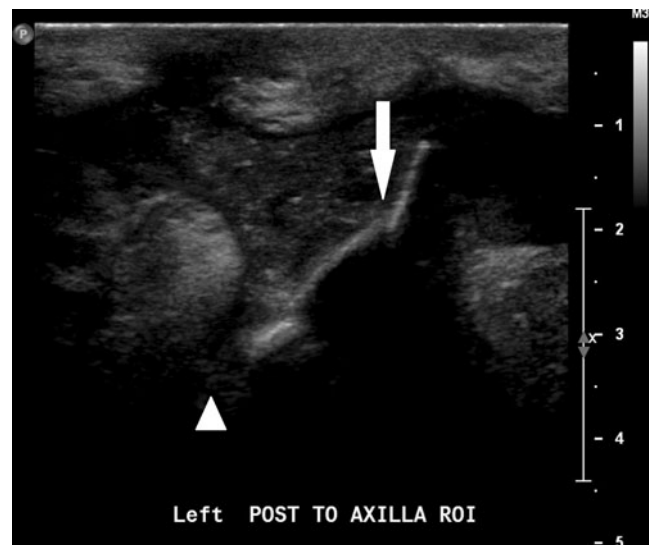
Left axillary ultrasound image showing foreign bodies within the left axillary region measuring 4.6×3.4 cm (arrow) that were 5 mm from the skin surface. There was also a smaller piece superior to the largest fragment measuring 6 mm, 4 mm from the skin surface. Concern was raised for a possible small fluid collection, abscess formation adjacent to the foreign bodies (arrowhead)
